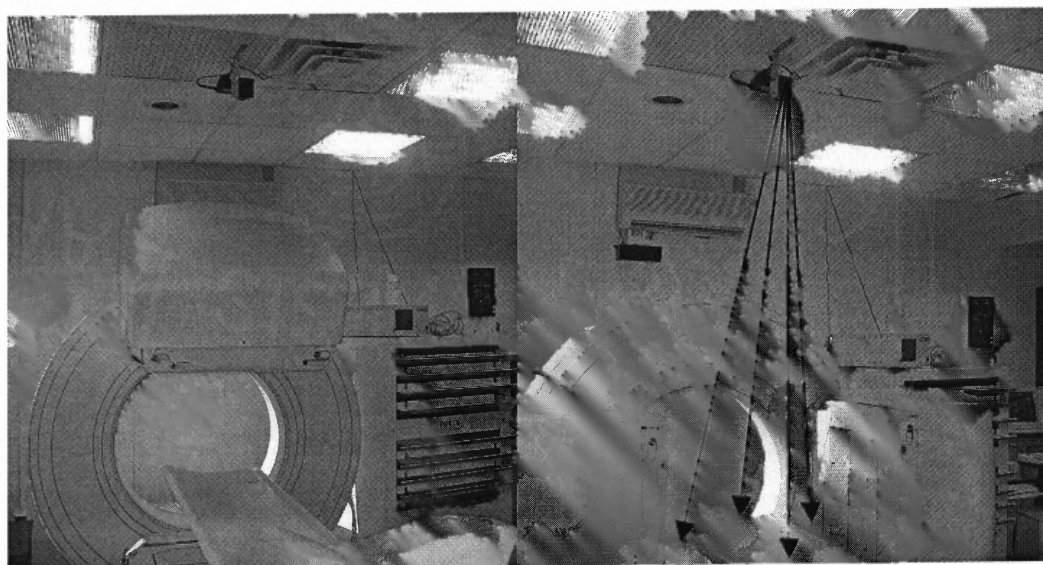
Visual Camera mounted above gamma camera. Gamma camera head is in horizontal plane for scintigraphic view (left panel) and is rotated to the vertical plane for visual camera acquisition (right panel). Field of view of the visual camera (arrows) is centered on the scintigraphic field of view.
